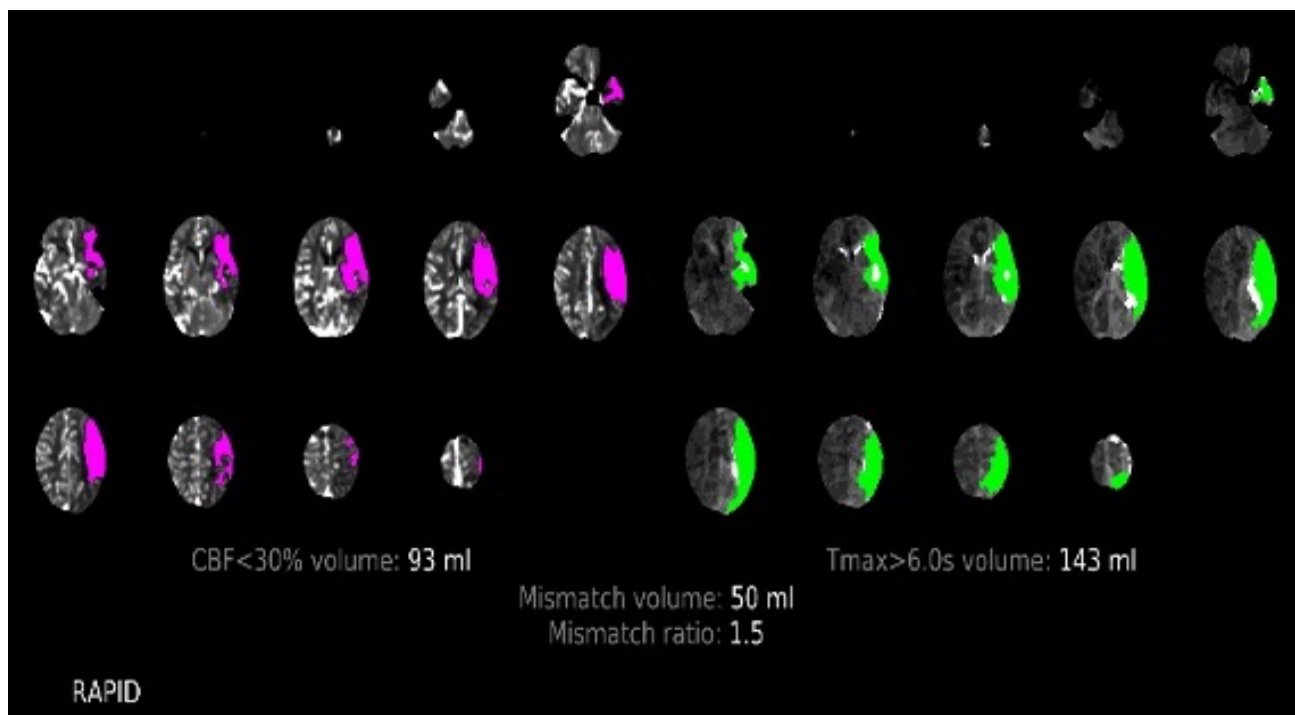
CT Perfusion scan of the patient: Core infarct volume (as indicated by the CBF <30% volume) = 93ml ; Total hypoperfusion volume (as indicated by the Tmax >6.0s volume) = 143ml
